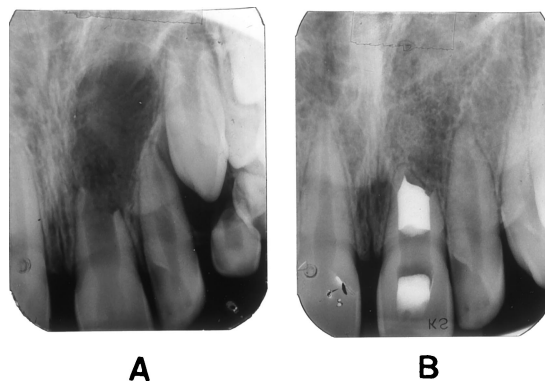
A typical case of $\text{Ca}(\text{OH})_2$ apexification. (A) Radiograph at initial examination. Tooth #9 has a nonvital pulp, a “blunderbuss” immature apex, and a large periradicular area of rarefaction. (B) Radiograph ~2 yr later at obturation visit with soft gutta-percha and sealer. There has been complete periradicular repair with restitution of normal thickness ligament space and lamina dura. Note how the obturation material adapts to the apexification “cap,” outlining its irregular inner surface. The rather thin “cap” has apparently sealed the canal preventing any extrusion of sealer or soft gutta-percha. The “cap” has spanned the gap between the tips of the flared apex, adding very little to the length of the root.
